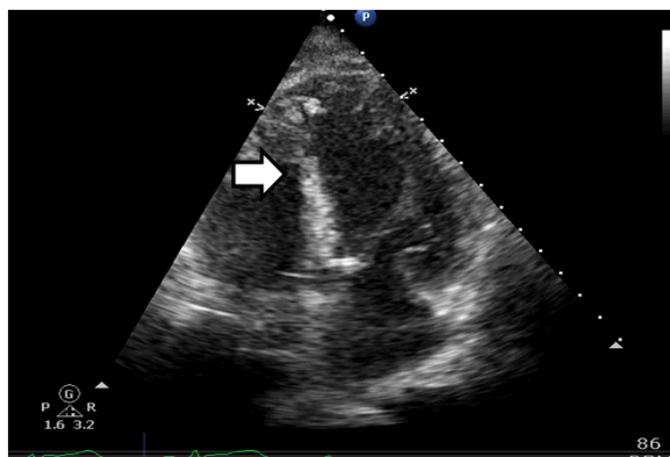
Four-chamber echocardiogram view. Arrow indicate the surgical reparation site
